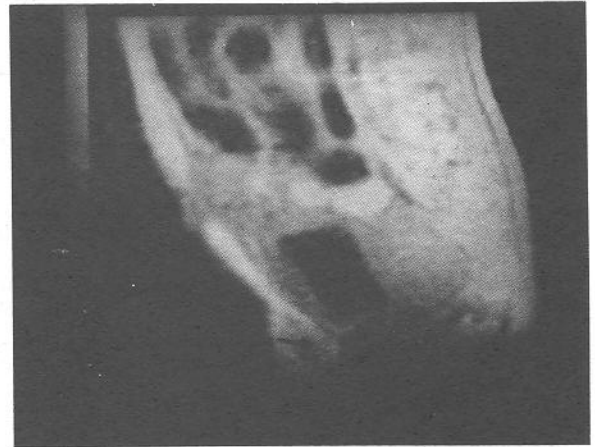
a) MRI study obtained postoperatively revealing tethering cord (arrow), b) pelvic structures.
